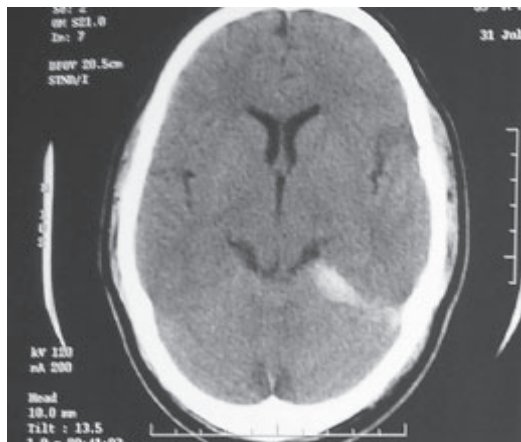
CT showing tentorial SDH
